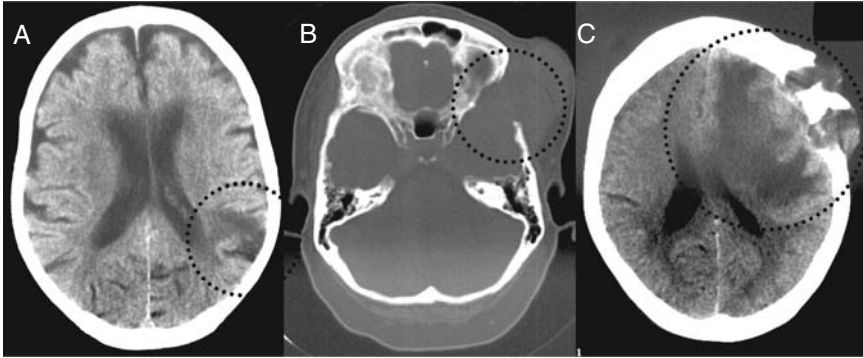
CT scans of the head (in axial orientation) showing regions of abnormality (enclosed by broken circles). A. Residual brain injury following a stroke where the blood supply was deprived to the injured region. B. An abnormality of bone: erosion of bone has taken place as a result of a tumor. C. A tumour has invaded both brain tissue as well as bone. Fluid build-up (oedema) in the surrounding tissue has created some compression of the invaded cerebral hemisphere, as seen by the compressed cerebral ventricle on the affected side. The other cerebral hemisphere has also been compressed across the midline.
